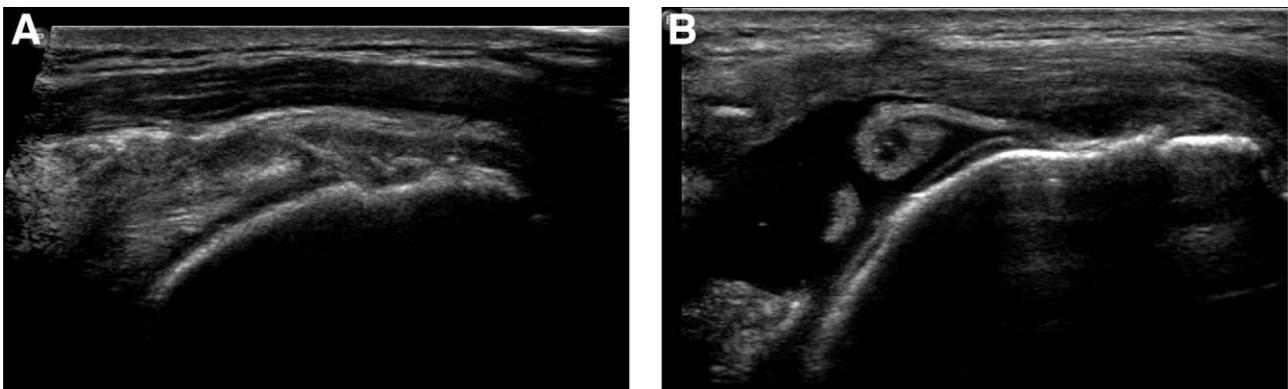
(A) Coronal ultrasound image demonstrating intact repair, with tissue extending to the greater tuberosity. (B) Coronal ultrasound image demonstrating recurrent defect, with tendon retraction.
